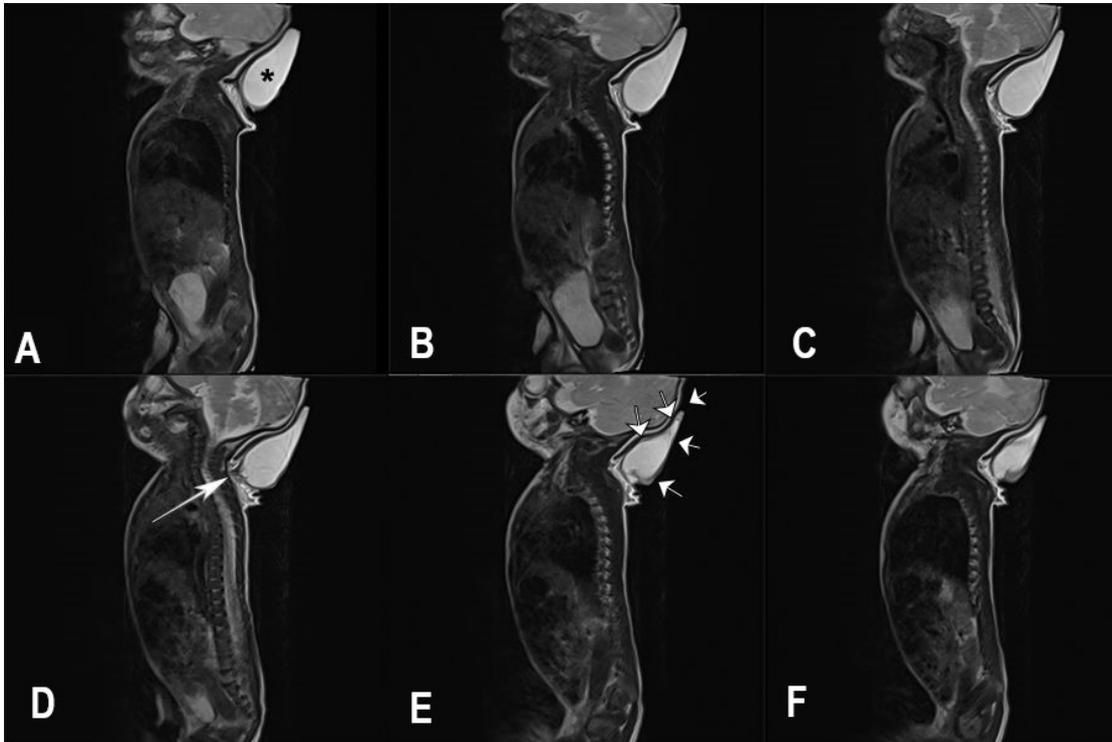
Neonatal MRI. A-F: T2-weighted images, sagittal sections. A: The meningocele sac (Asterix). D: The connection to the spinal canal (Arrow). E: Skin covering the meningocele sac (Arrows).
